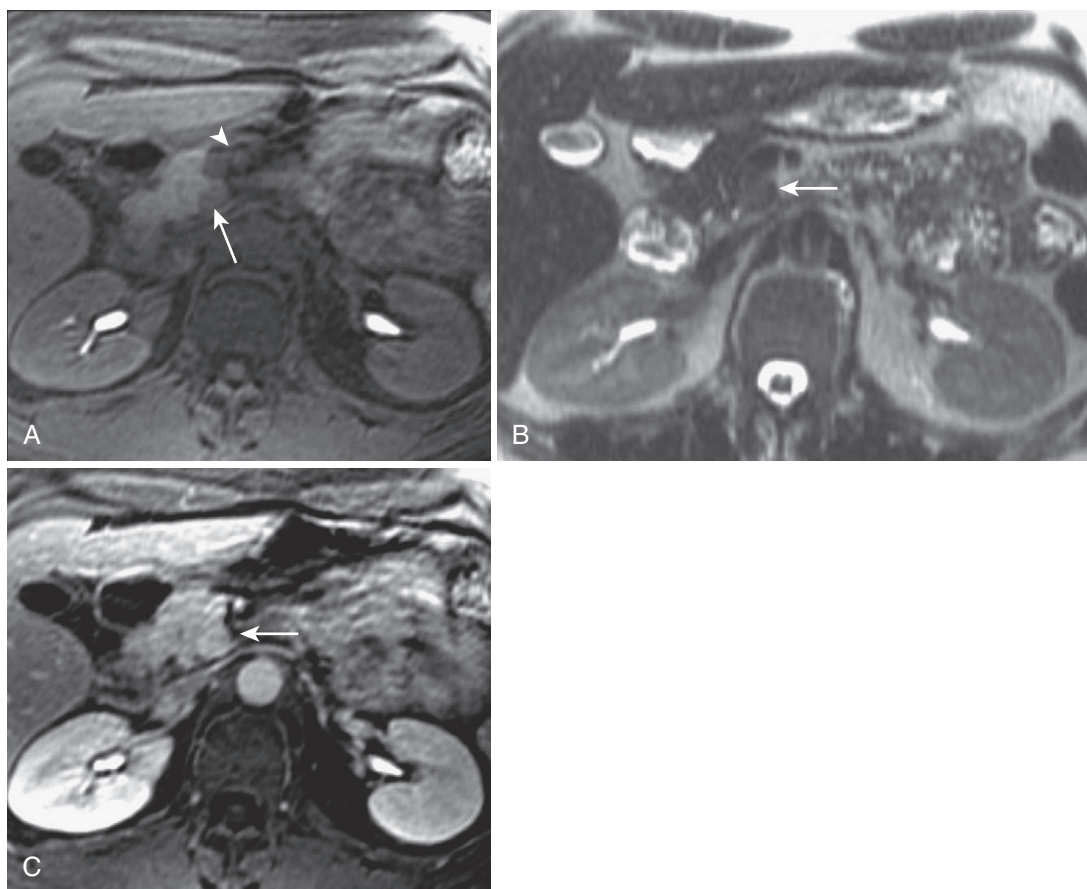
Insulinoma. A, The precontrast T1-weighted fat-suppressed image in a patient with hyperinsulinemia reveals a small hypointense lesion (*arrow*) in the uncinate process behind the superior mesenteric vessels (*arrowhead*). The T2-weighted image (B) shows mild lesional hyperintensity (*arrow*) and the postcontrast image (C) demonstrates the hypervascularity typical of an insulinoma (*arrow*).
